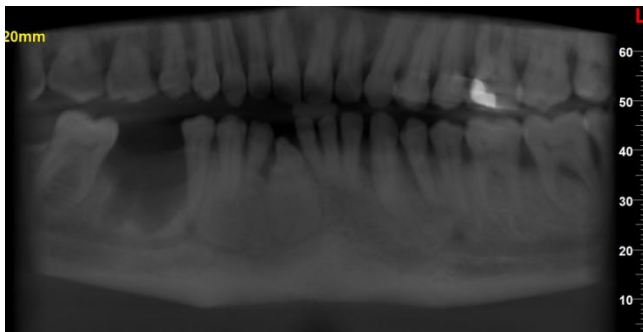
Postoperative six months radiographic evaluation showing bone fill in 26
